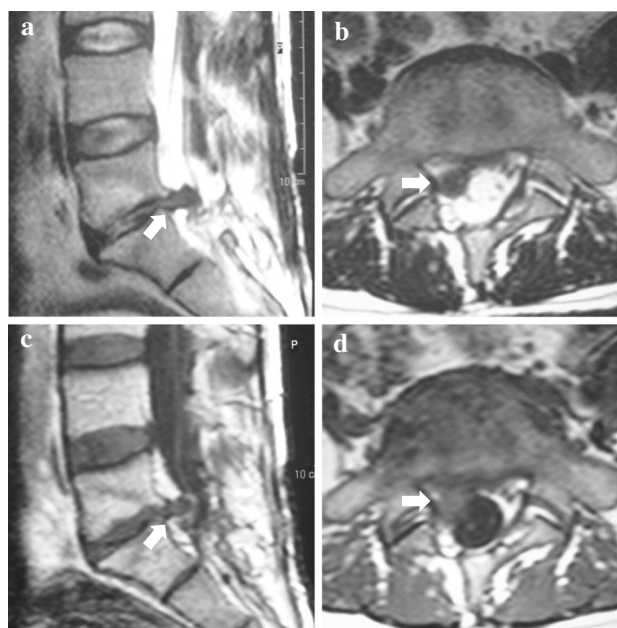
MRI images of a 45-year-old male patient who presented a right-sided L5–S1 RLDH (white arrows) 25 months after the index surgery for the original same-sided LDH [T2 axial (a) and sagittal (b), contrast-enhanced axial (c) and sagittal (d)]
